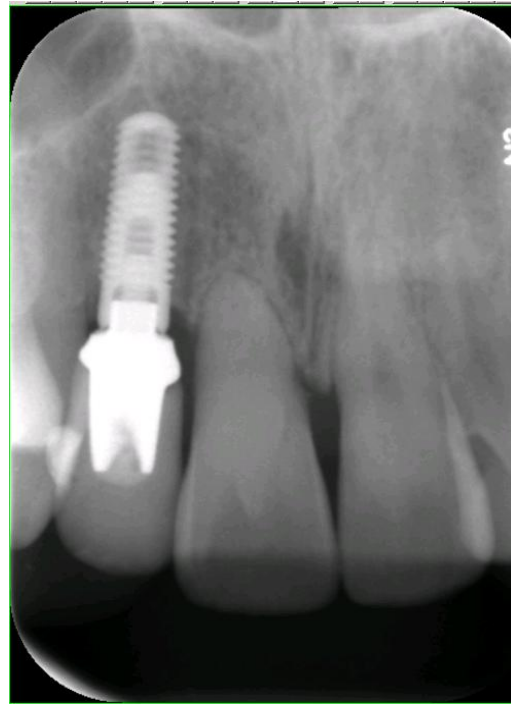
12-Month Follow-Up Radiograph
